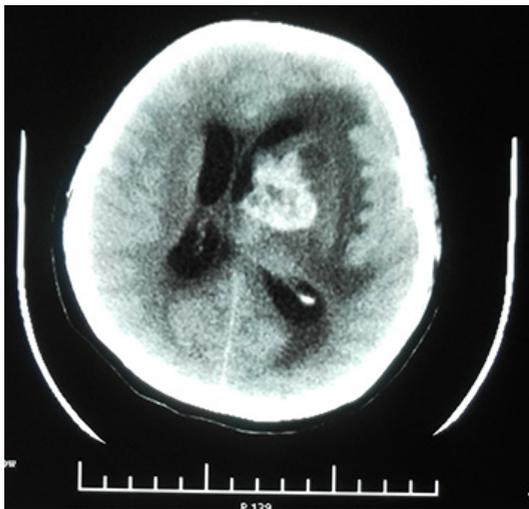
CT image posterior to the first surgery.
